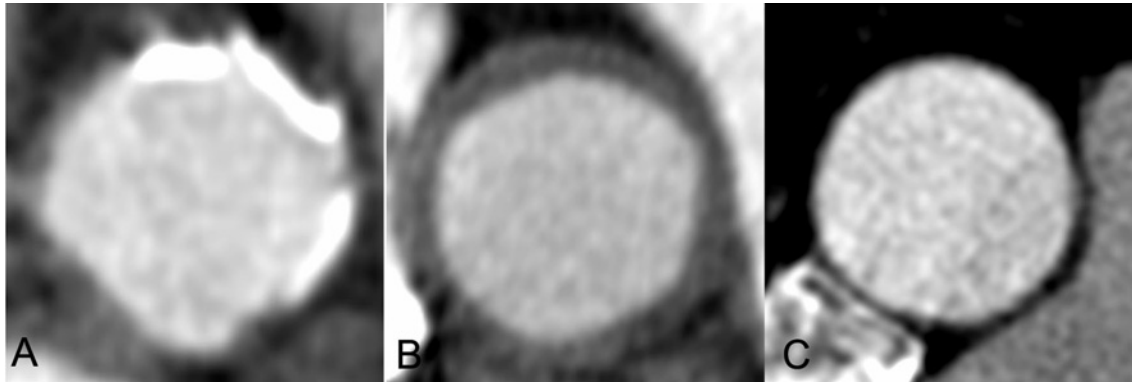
Preoperative computed tomography scan of the ascending aorta showing different atherosclerotic plaque types. A, Hyperdense, calcifying plaque (white). Intra-aortic balloon rupture occurred in this patient. B, Hypodense, noncalcifying plaque (dark) surrounding the complete ascending aortic lumen in a “rim-like” manner. C, There are no signs of atherosclerosis; note that the ascending aortic lumen is sharply delineated and smooth.
